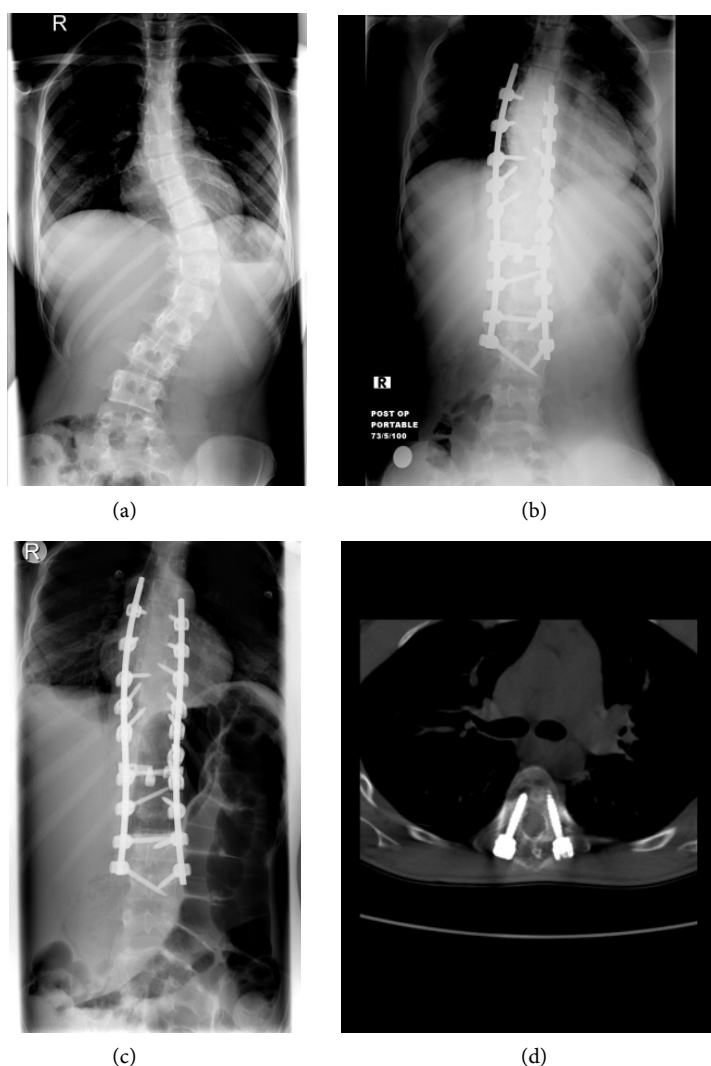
(a)-(d) Maintained correction over 5-year period with no complications. (a) Preoperative whole spine PXR AP view showing marked smooth left dorso-lumbar scoliosis. Cobb angle = 45°; (b) immediate post-operative scan with good correction and satisfactory alignment. Cobb angle = 9°; (c) 2-year follow up scan showing maintained correction with no significant change in the Cobb angle measurement; (d) axial CT scan (bone window with OMAR software) at 5-year interval showing optimum screw positioning with no evidence of loosening or pull-out.
